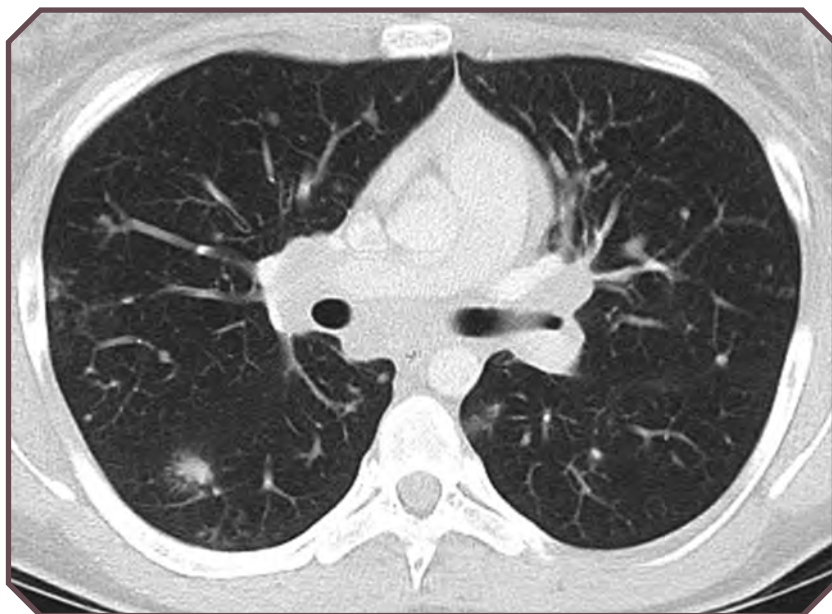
Histoplasma pneumoniae* in the same 16-year-old girl as in Figure 61-1. Axial chest computed tomographic image demonstrates multiple nodules of variable size and mediastinal adenopathy.
